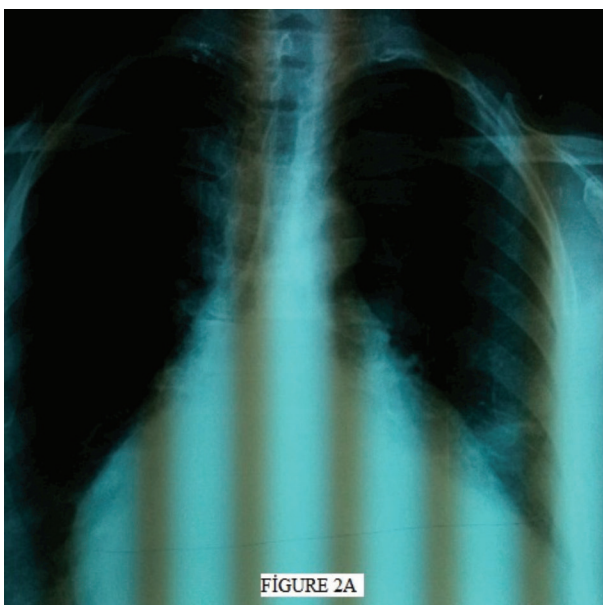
A preoperative chest radiograph (A) and an early postoperative chest radiograph (B).
